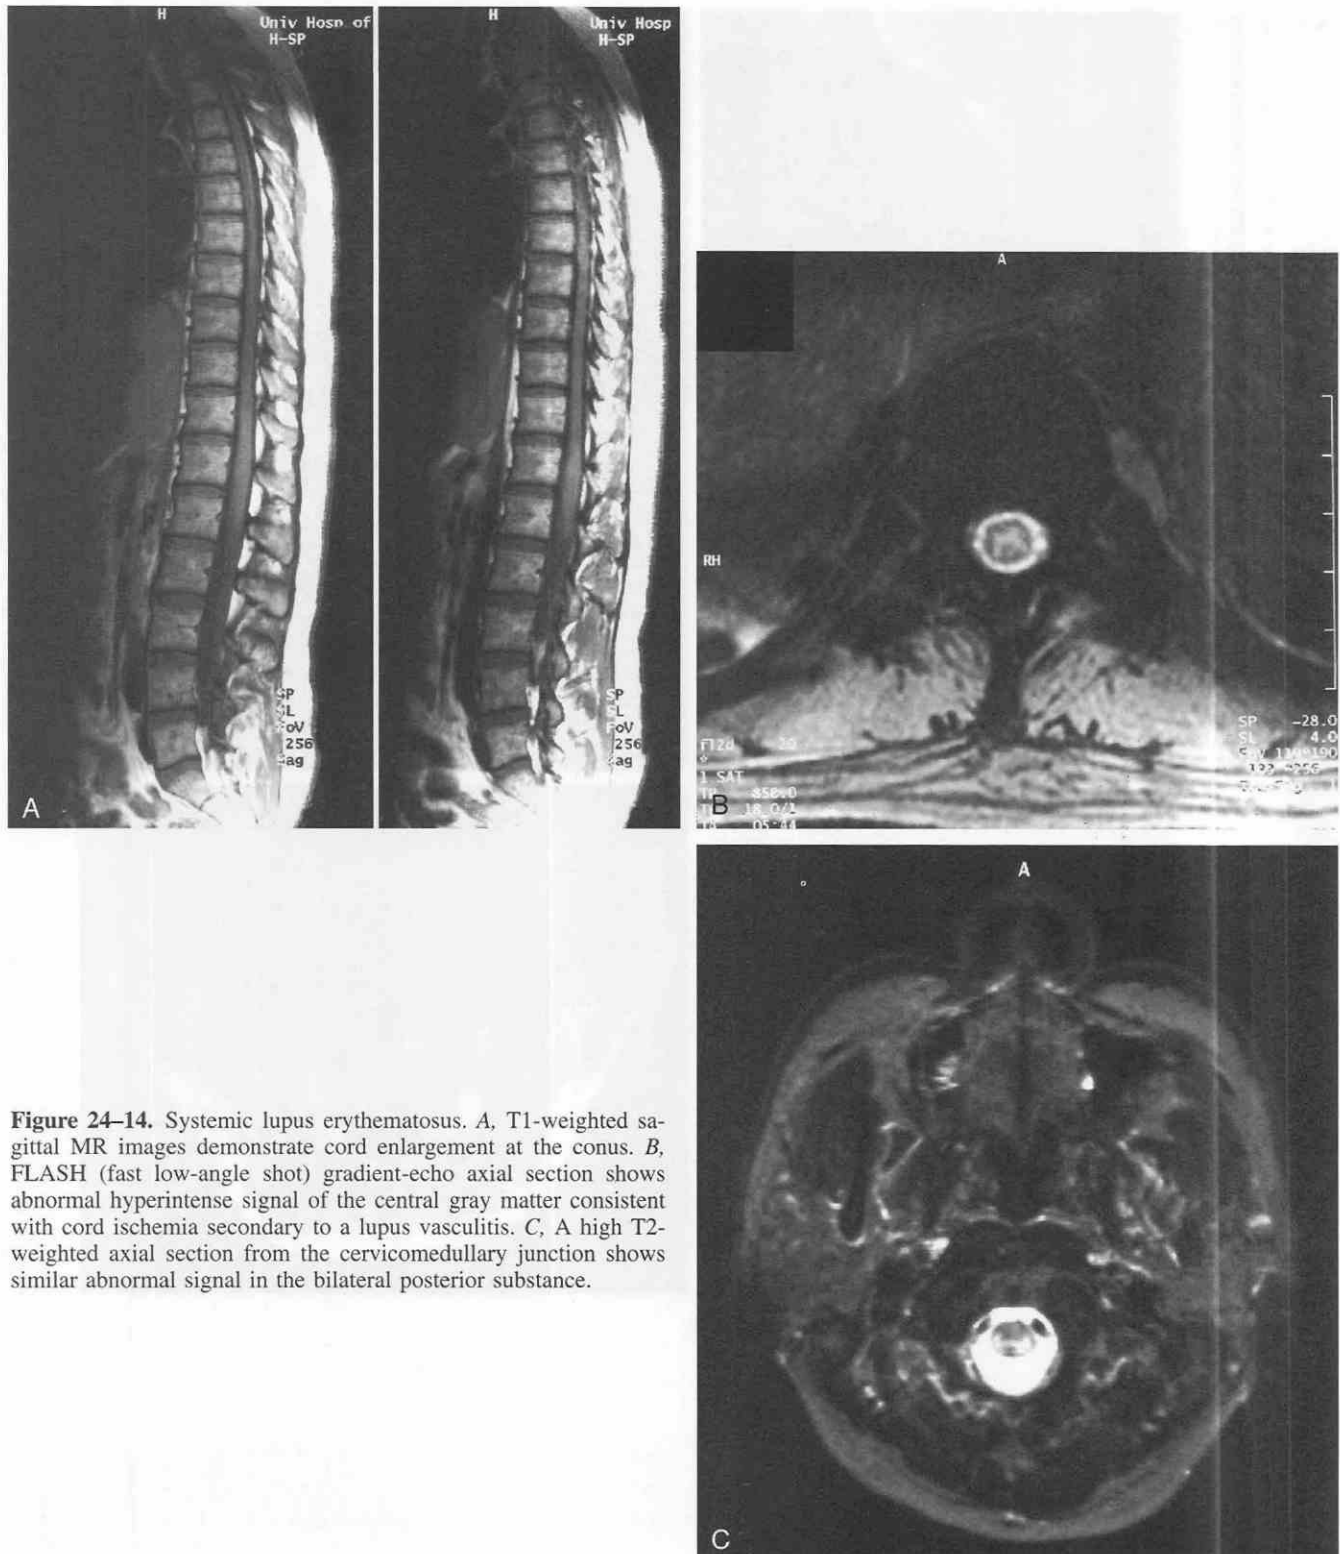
Systemic lupus erythematosus. A, T1-weighted sagittal MR images demonstrate cord enlargement at the conus. B, FLASH (fast low-angle shot) gradient-echo axial section shows abnormal hyperintense signal of the central gray matter consistent with cord ischemia secondary to a lupus vasculitis. C, A high T2-weighted axial section from the cervicomedullary junction shows similar abnormal signal in the bilateral posterior substance.
